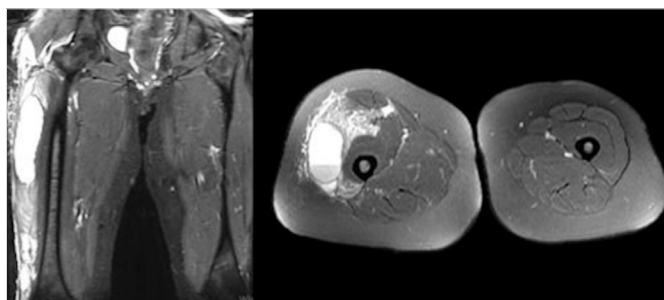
Coronal and axial magnetic resonance image of the thighs, showing a large intramuscular hematoma, as well as widespread muscle edema in the lateral compartment of the left thigh.
